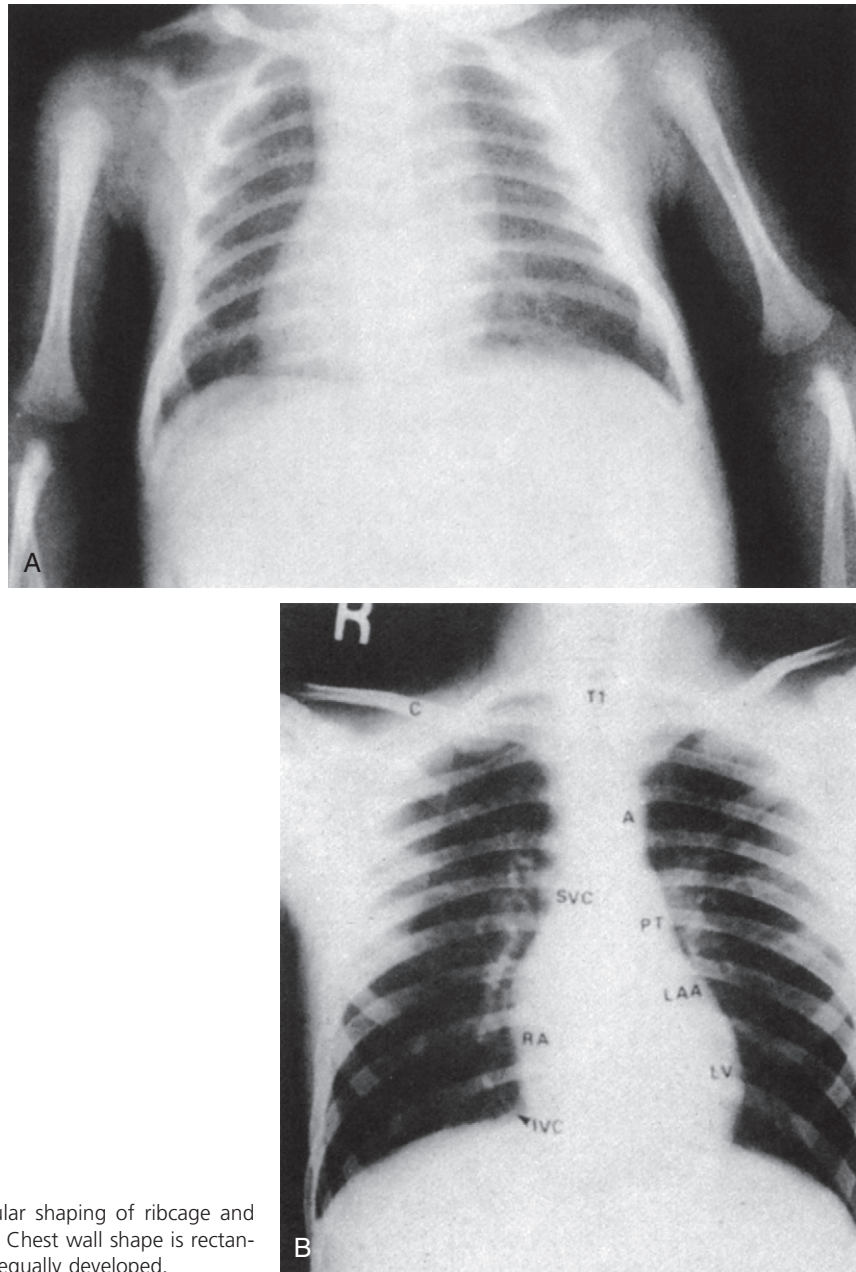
A, Chest x-ray of a newborn. Note triangular shaping of ribcage and narrow intercostal spacing. B, Typical adult chest x-ray. Chest wall shape is rectangular, ribs angled downward, upper and lower thorax equally developed.
